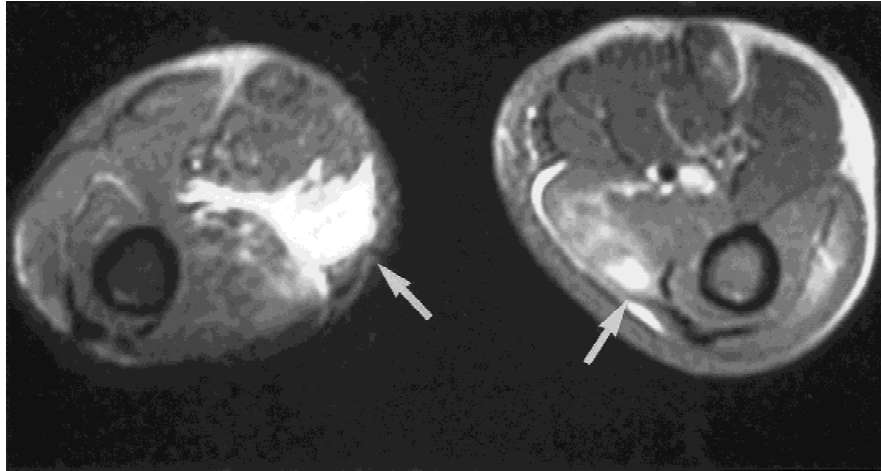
Case 1. Magnetic resonance imaging scan of lower extremities (thighs), demonstrating focal areas of T2 signal within the quadriceps bilaterally (arrows), within most of the left sartorius and soleus muscles, and in all compartments of the right lower leg (not shown). There is thickening of adjacent fascia with associated subcutaneous edema. Findings are consistent with edema or inflammation.
